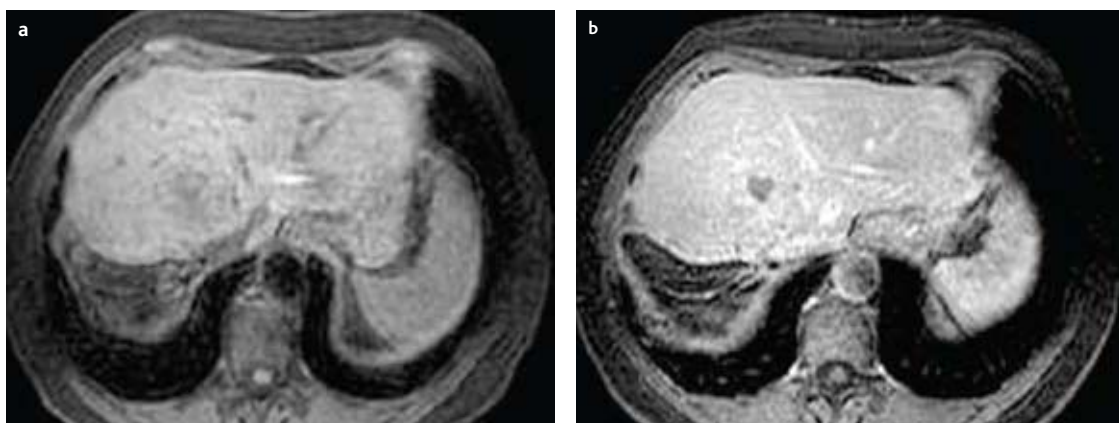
(a) Pre-embolization MR image shows a relatively well defined HCC of 5 cm in diameter near the diaphragm. (b) One month after two superselective embolization sessions with DC Bead, the lesion shows complete necrosis and considerable shrinkage in size.
